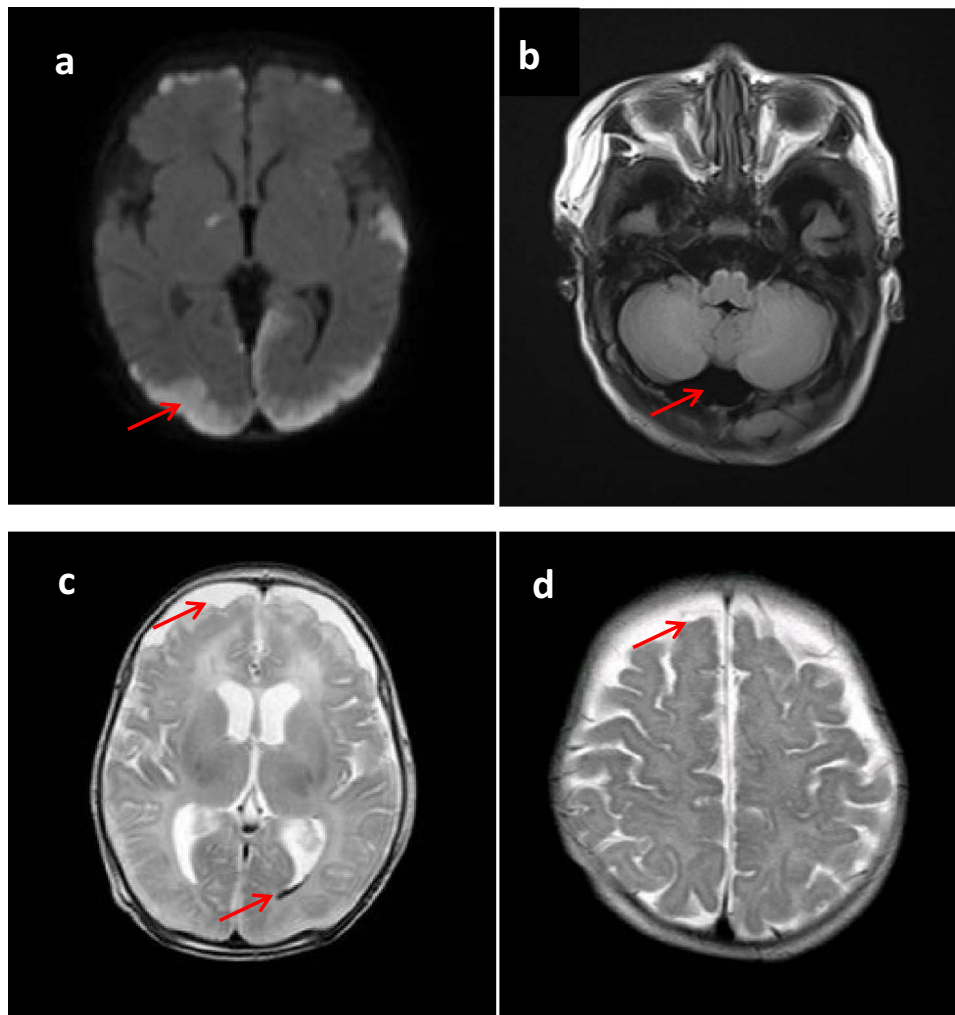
Head magnetic resonance imaging of late-onset GBS meningitis in the twins and the compatriots after admission. (a): Increased subdural effusion and meningoencephalitis were revealed in compatriot A. (b): Formation of occipital arachnoid cyst was found in compatriot B. (c): Bilateral frontal subdural empyema and hemorrhage was indicated in twin A. (d): Suppurative meningitis was diagnosed in twin B. The red arrow points to the focal area.
